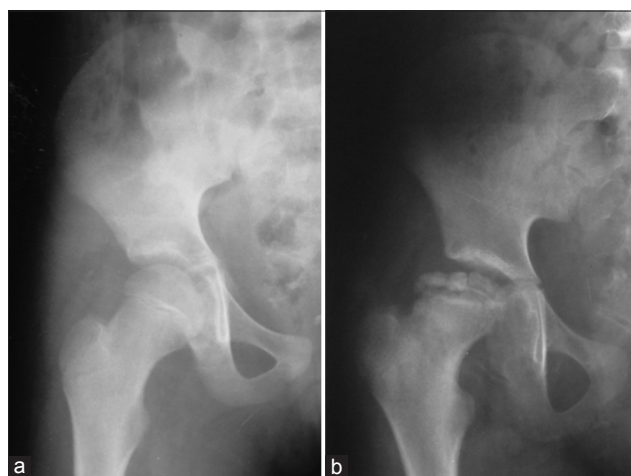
X-ray right hip joint anteroposterior view of a 11-year-old girl child showing (a) pretreatment normal type radiographs. However, there was associated tubercular abscess in right hip region. (b) Following treatment, Perthes radiological type became manifest with epiphyseal fragmentation. There was fixed flexion deformity of 20° in the hip with no other movements possible. The outcome was classified as poor
